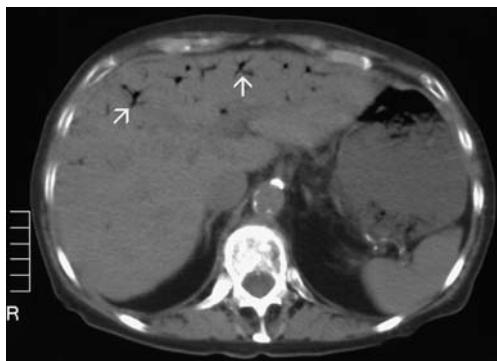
A 73-year-old women (case # 11) with an abdominal aortic aneurysm and atrial fibrillation. Unenhanced CT scan shows linear gas collections in peripheral portal venous branches (arrows) extending close to the hepatic capsule
